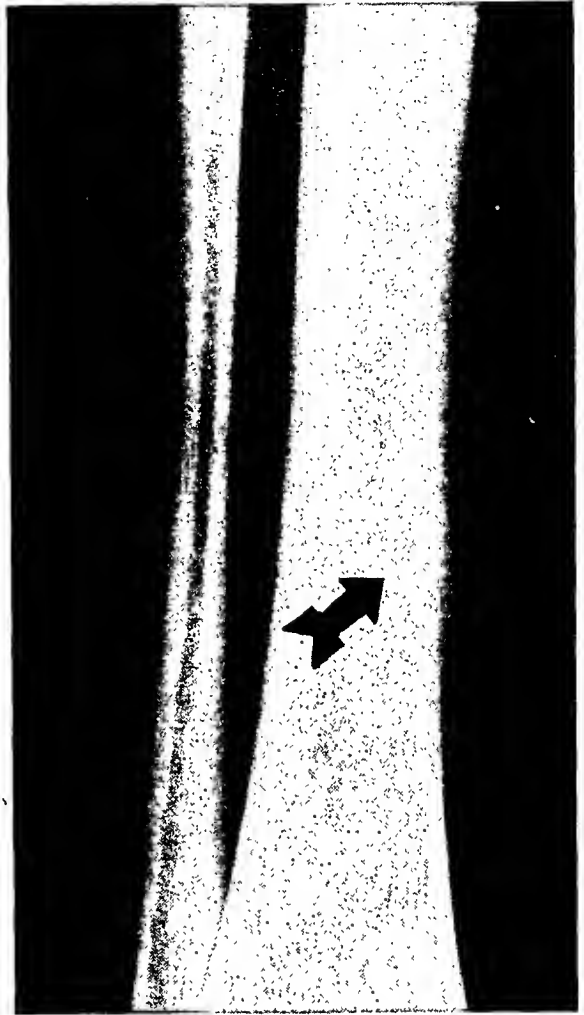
Case 3: Anteroposterior roentgenogram of the right leg made one month after the onset of symptoms, showing an oblique fracture through the cortex of the medial surface of the tibia in the lower third. A cap of well defined callus covers the fracture.
